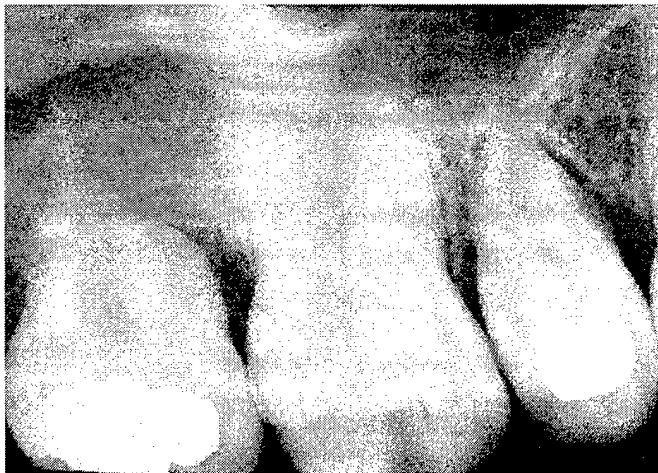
Periapical radiograph demonstrating crescent pulpal obliteration and short root structure of maxillary molar (Tooth No. 2).
